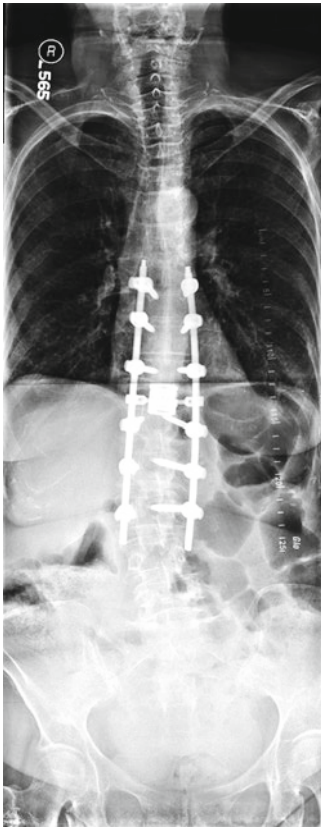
This AP radiograph is an example of instrumentation options. The patient has a T8–L2 pedicle fixation with a T12 corpectomy and placement of an expandable cage
